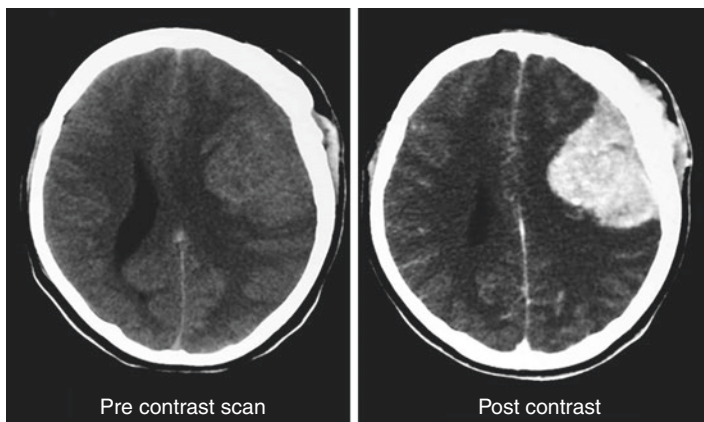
Shows the pre and post contrast CT scans of a 22-year-old male that presented with his first grand mal fit. He admitted to having a large mass on the left side of this head for over 1 year. This history clearly suggests a slow growing tumor like a meningioma. Identification of a mass lesion is so much easier if there is significant enhancement. The pre-contrast scan is same as in Fig. 5.2a. The effect of the contrast enhancement is obvious. Although the meningioma is isodense and can only be inferred from the mass effect (effacement of the sulci, compression of the left lateral ventricle and midline shift), the contrast enhancement makes it obvious
